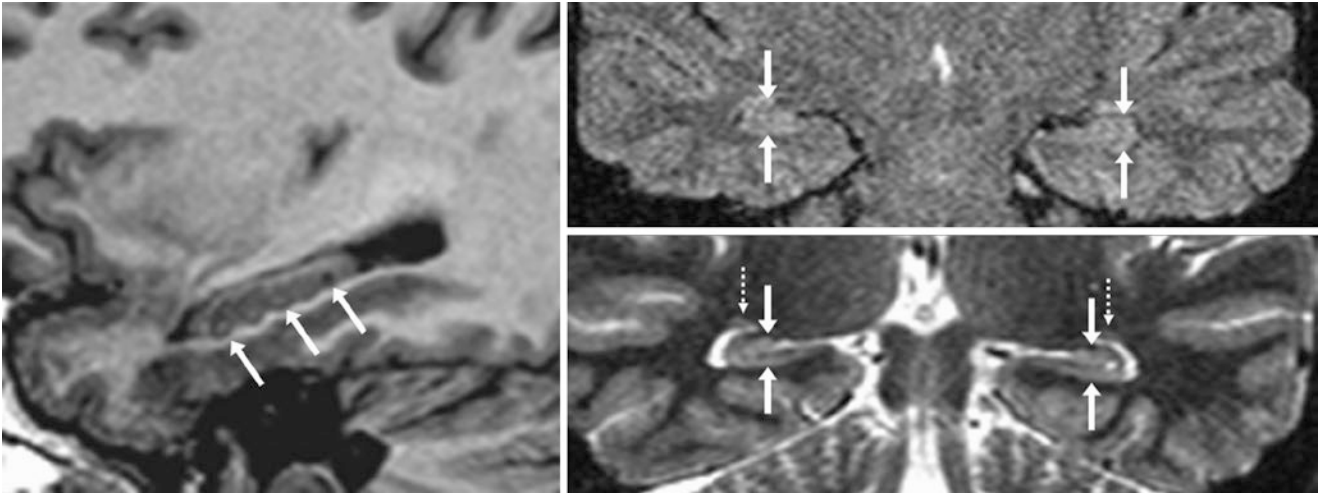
A 37 year old with a corrugated or undulating configuration of the right hippocampus (arrows) on a 1.5 T MRI with a 1-mm-thickness sagittal T1WI (left image). Coronal FLAIR (top right) and coronal T2WI (bottom right) confirm that there is no abnormality
